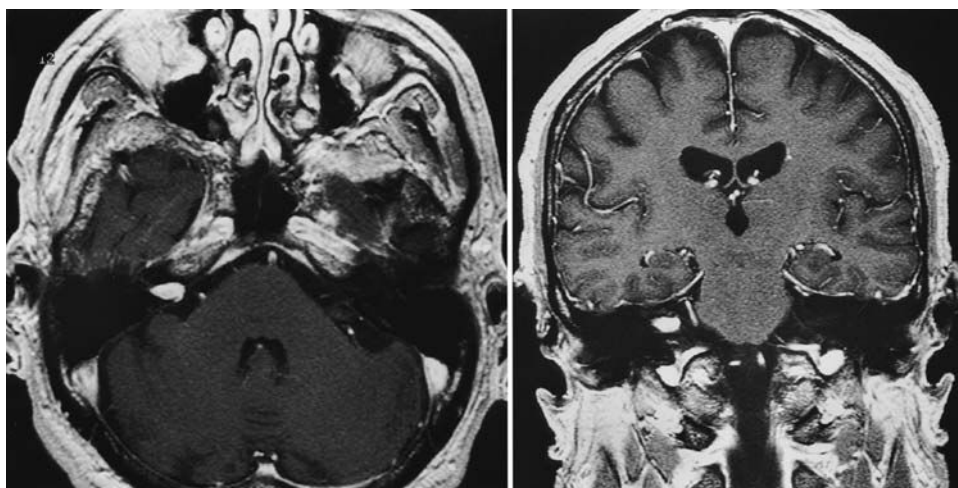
Axial (*left*) and coronal (*right*) MR images with gadolinium enhancement demonstrating a 1-cm right-sided intracanalicular tumor with a 3-mm extension into the right cerebellopontine angle.
